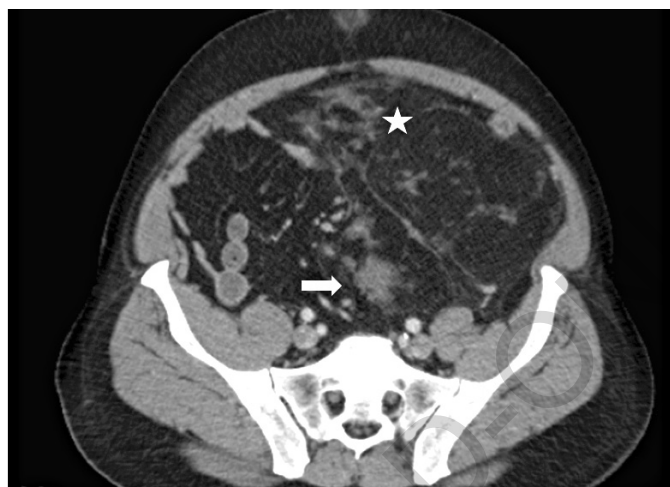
Well-differentiated liposarcoma. Axial contrast-enhanced CT image shows a large heterogeneous well-defined predominantly fat-containing mass with thick septa (asterisk) and soft-tissue nodular components (arrow).
